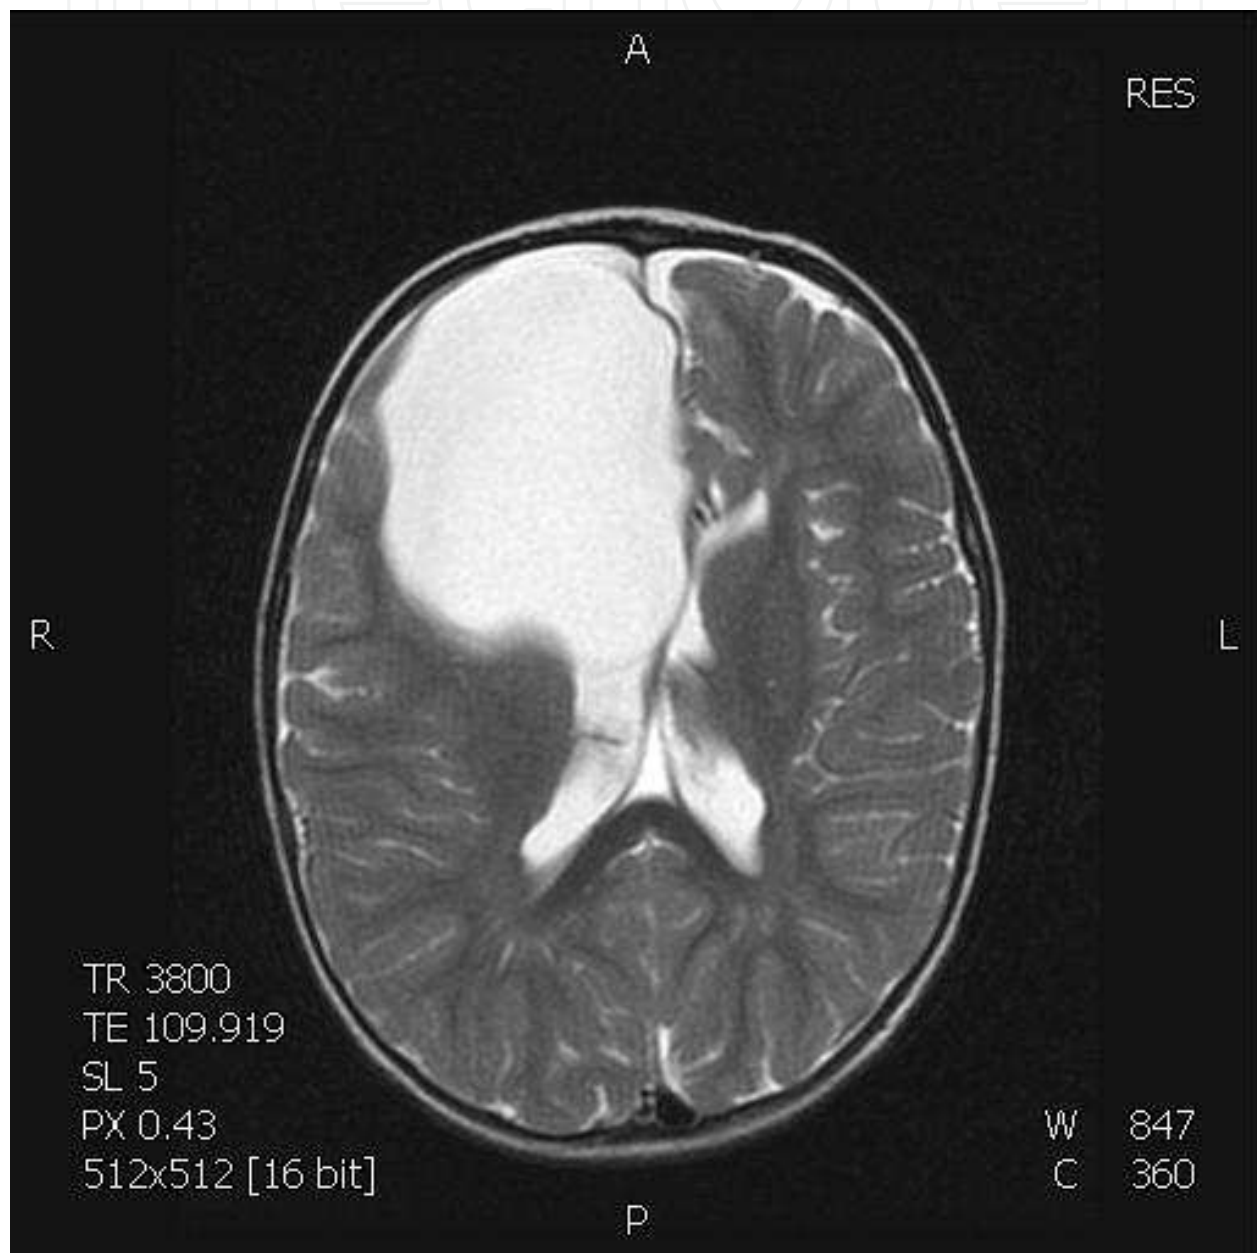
Porencephalic cyst: T2-weighted SE image displays a wide cyst in the left frontal lobe, which is connected to the lateral ventricle and causes a slight lateral midline displacement of the brain.
